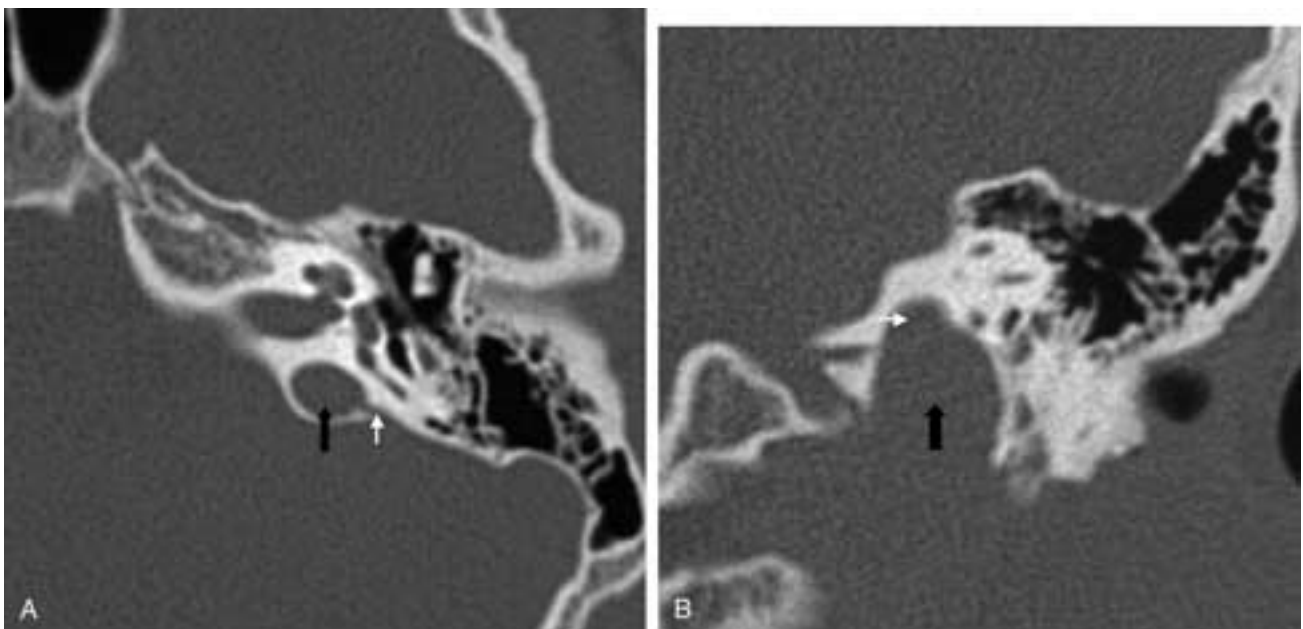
JD. A, Axial CT image of a JD (*black block arrow*) abutting the vestibular aqueduct (*white arrow*). B, Coronal CT image showing a jugular bulb (*black block arrow*) and a small diverticulum (*white arrow*) projecting superiorly toward the semicircular canals.
